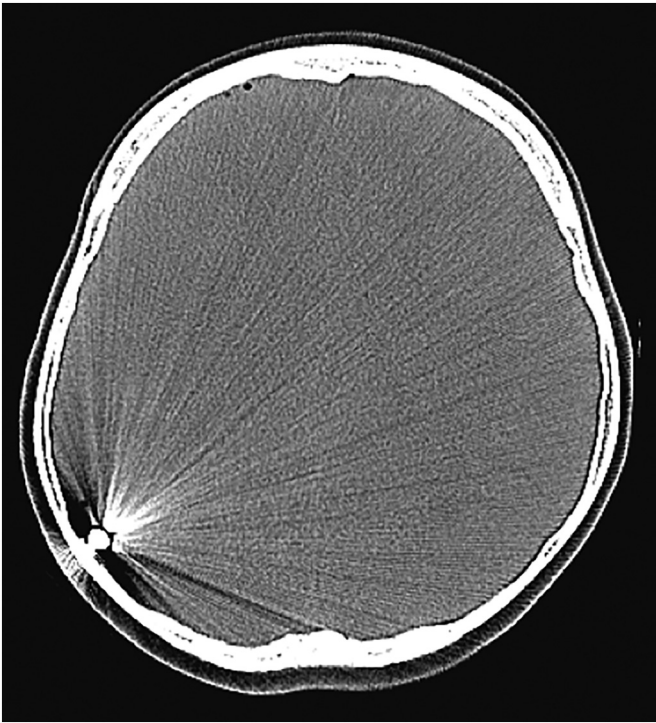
Axial computerized tomography (CT) image demonstrating a projectile from a ball-bearing gun, which penetrated the frontal bone and settled in the parieto-occipital region and resulted in subarachnoid hemorrhage.
